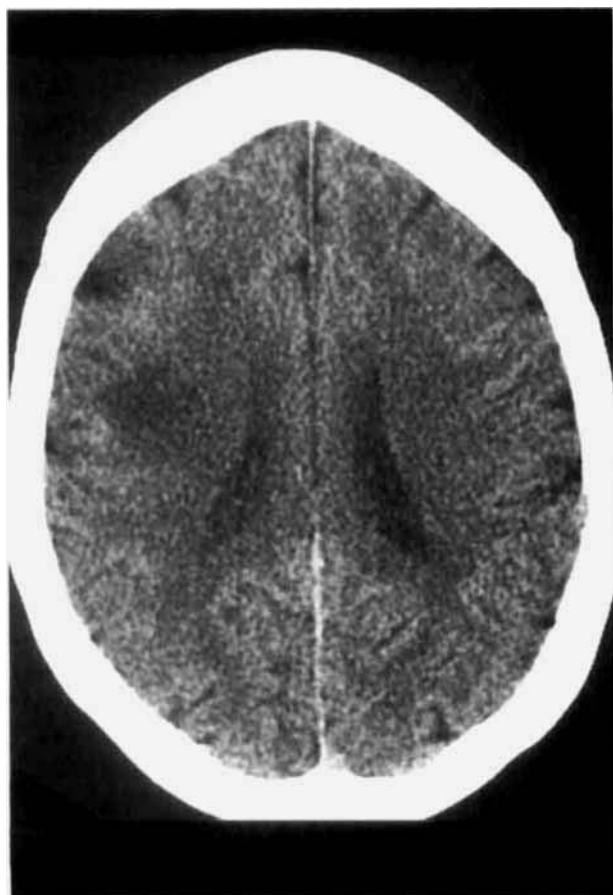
Contrast enhanced CT. A focal patch of hypodensity is seen within the corona radiata on the right. There is questionable faint enhancement at the lateral aspect of the lesion and fullness of the brain parenchyma at this site.
